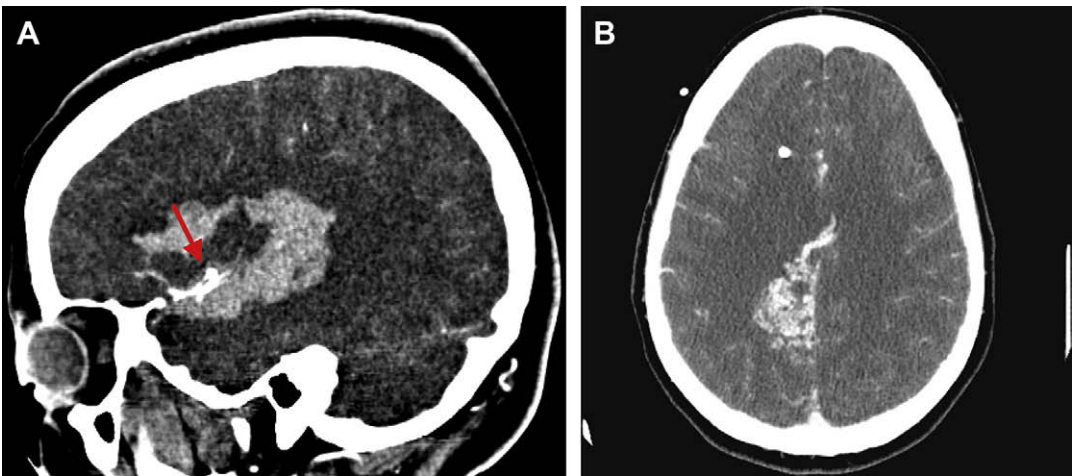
CTA demonstrating aneurysms and AVM. (A) Sagittal CTA image demonstrating a right MCA aneurysm (arrow) within the hematoma. (B) Axial CTA image demonstrating right frontal-parietal AVM with a draining vein anteriorly.
